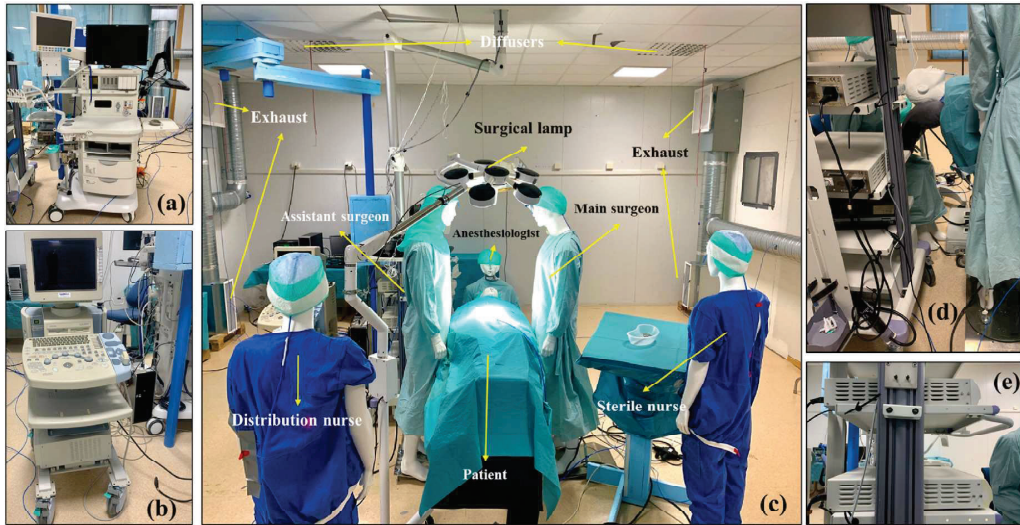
Medical equipment and layout in the operating room. (a) Anesthesia machine; (b) Ultrasonic imager; (c) the layout of the OR laboratory; (d) Endoscope imager; (e) The cooling fan of the endoscope imager.
